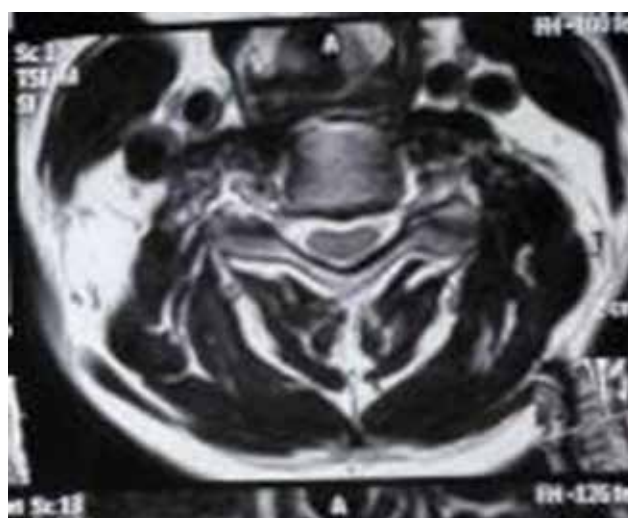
MRI T2W image axial section shows left C6 nerve root compression.
